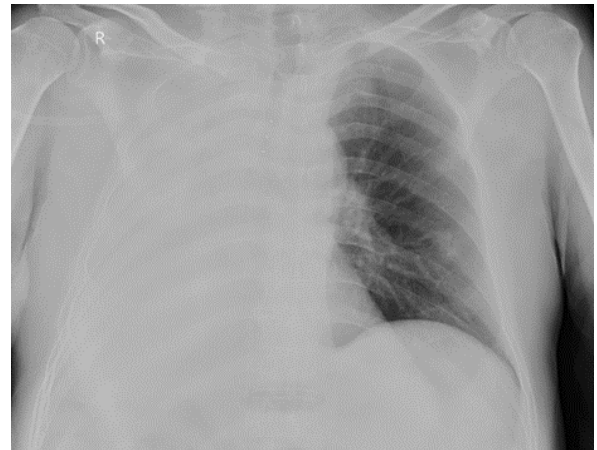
Chest X-ray upon admission, showing complete opacification of the right lung
